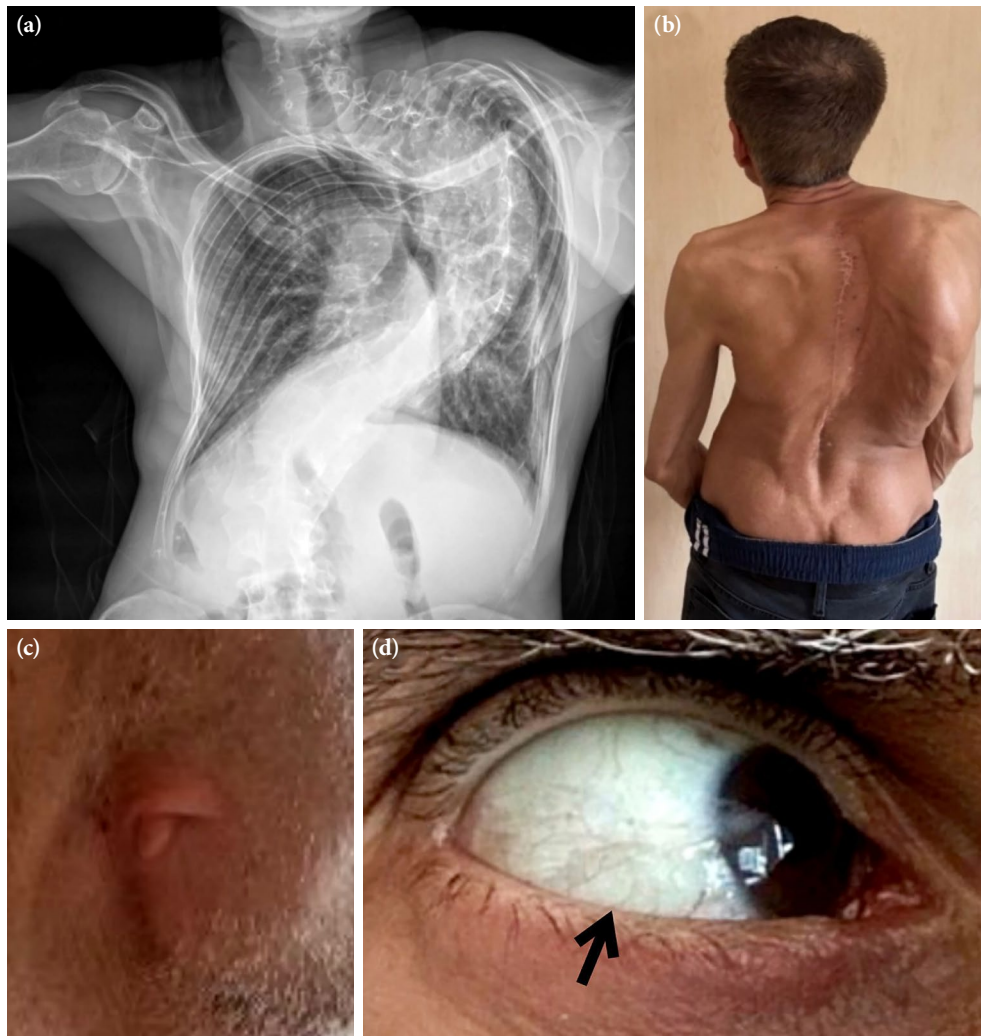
(a) X-ray image of the thoracic and lumbar spine showing severe scoliosis. (b) Clinical photograph of the patient demonstrating a severe spinal deformity. (c) Absence of the right external auditory canal and auricle, along with periauricular skin tags. (d) Limbal dermoid (ocular mass typical of Goldenhar syndrome).
